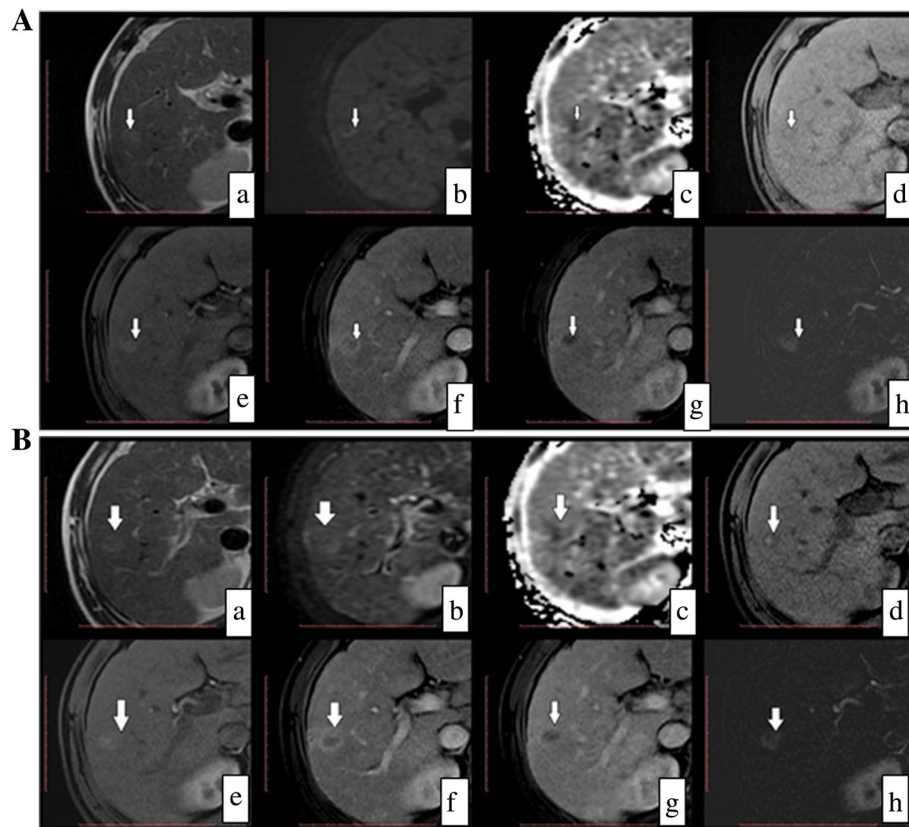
A 67-year-old male patient with hepatitis-related liver cirrhosis and single segment V/VI HCC lesion. He had a TACE session and came for follow up 1 month post TACE and another short term follow up after 2 months. (A) Follow up dynamic MRI 1 month post TACE. a T2WI, b DWI image, c ADC image, d T1WI, e late arterial phase, f portal phase, g delayed phase, and h late arterial subtracted image. The treatment zone exhibits high signal in T1WIs and intermediate to high signal in T2WIs with thick peripheral area of enhancement suggestive of residual disease. Subtraction clarified this pattern of enhancement by removing the native high T1WIs signal. (B) Short-term follow up dynamic MRI 2 months post TACE. a T2WI, b DWI image, c ADC image, d T1WI, e late arterial phase, f portal phase, g delayed phase, and h late arterial subtracted image. Note that the lesion appears with same pattern of contrast enhancement and slight increase in size confirming the residual disease
